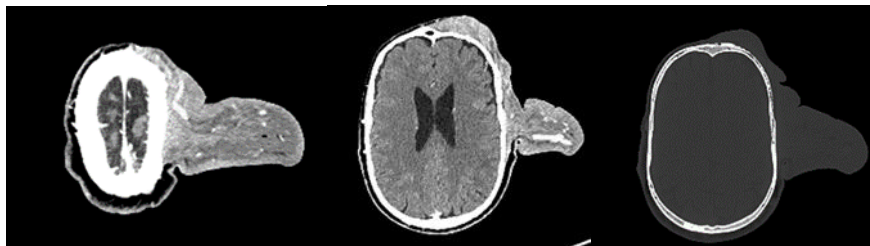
CT Scan Showing A Large Extracranial Mass With Intratumoral Veins
